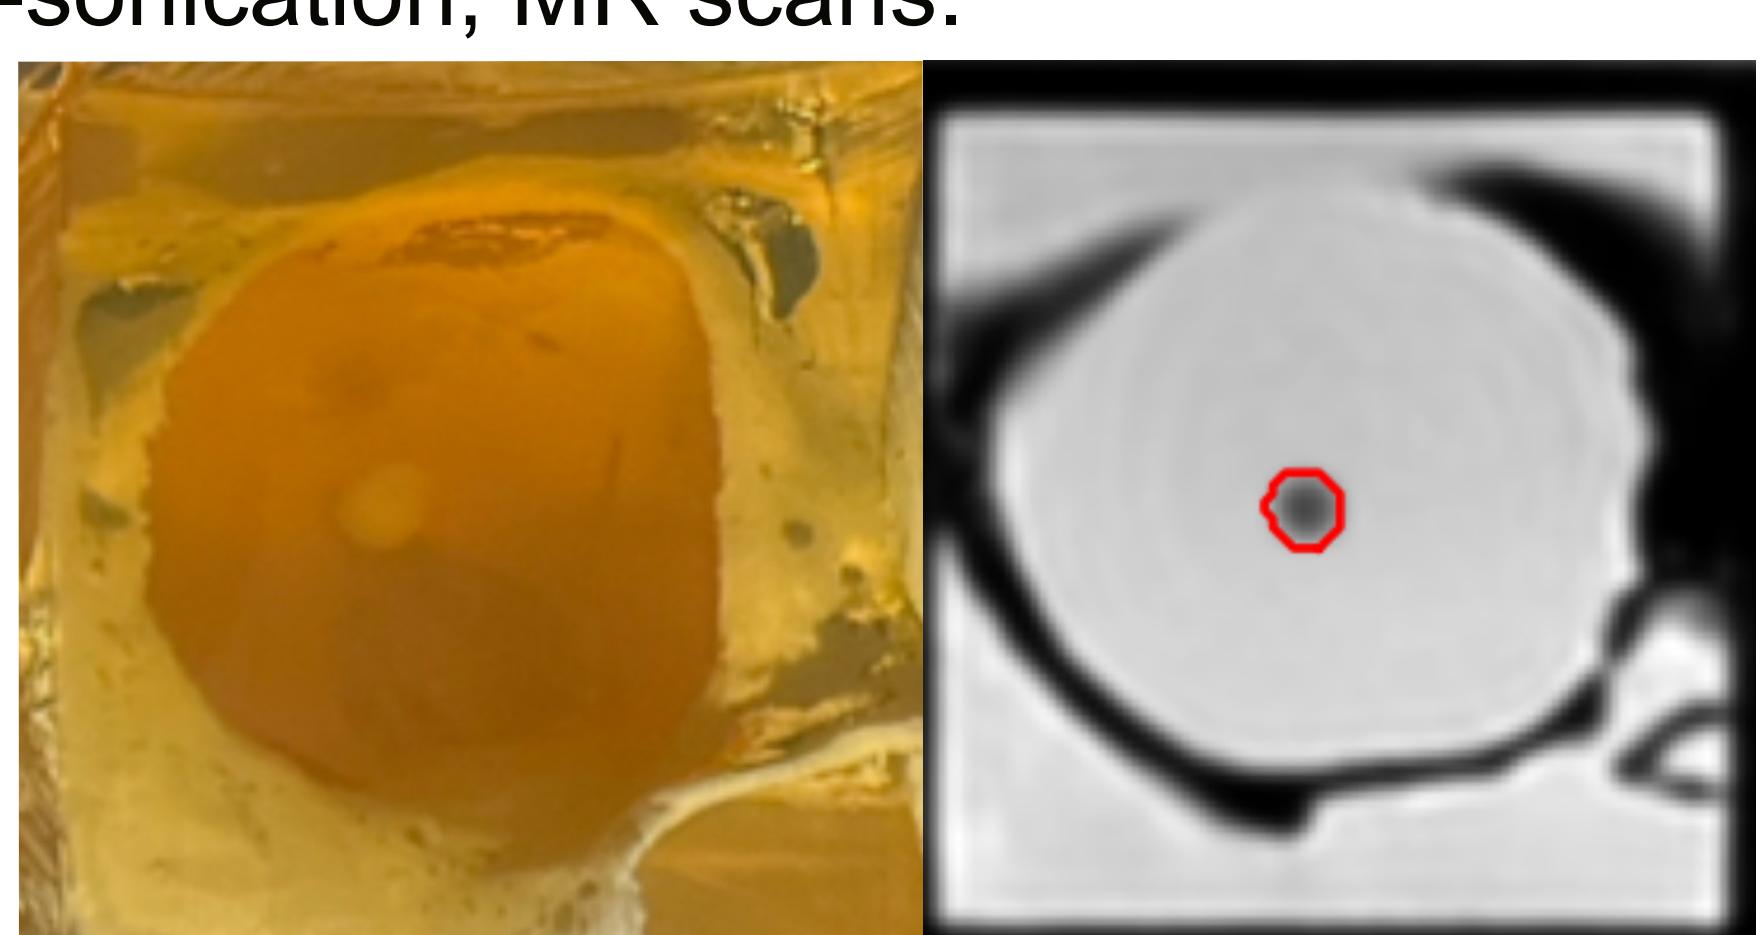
Denatured BSA region (left) and corresponding segmentation of T2-weighted MR scan (right)
